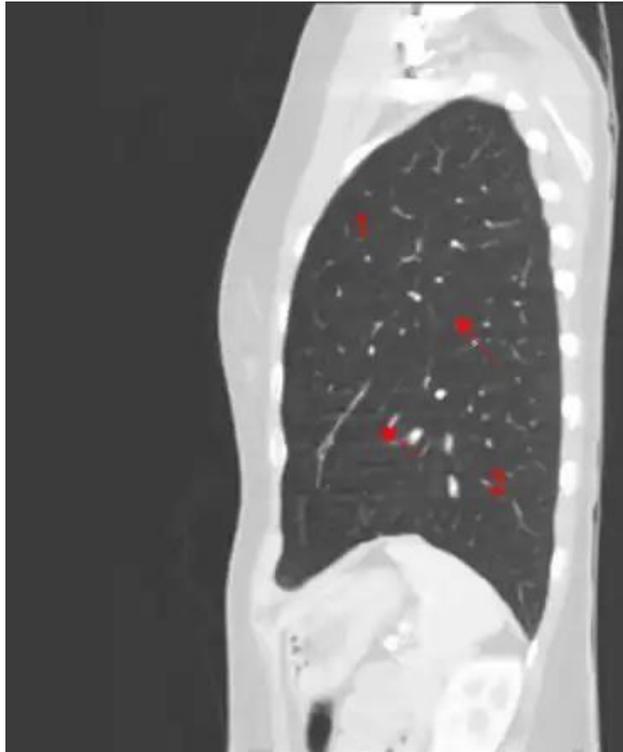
Sagittal reconstruction in pulmonary window depicting the CT anatomy of left lung; 1, Left upper lobe; 2, Left lower lobe; Red arrow, Major fissure.
